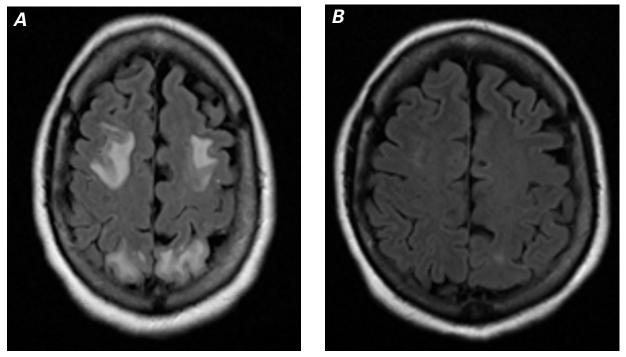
Magnetic resonance images. A) Upon the patient's presentation with seizures, multiple areas of high signal intensity within the cortex of the bilateral frontal and parietal lobes were seen, along with subtle signs of abnormality in the temporal and occipital cortices.
